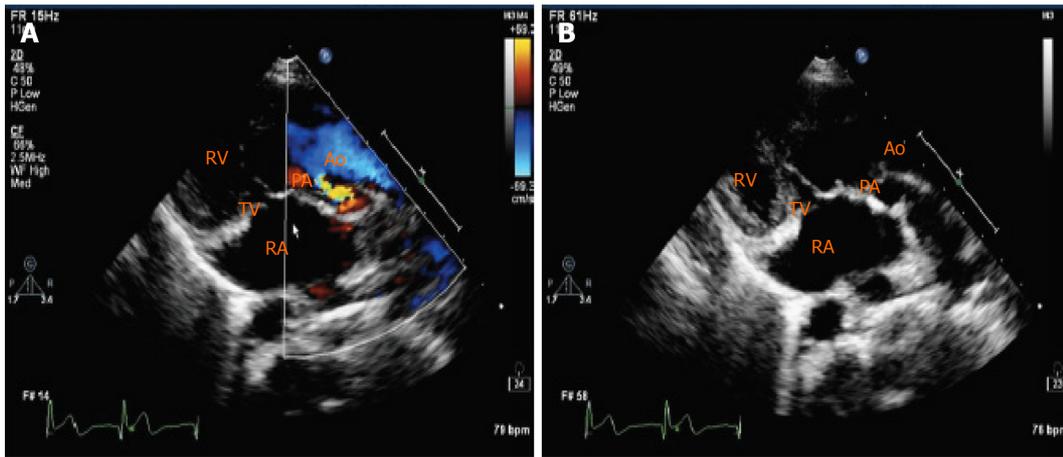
Preoperative transthoracic echocardiography showed a double outlet right ventricle and pulmonary artery stenosis. RA: Right atrium; RV: Right ventricle; TV: Tricuspid valve; Ao: Aorta; PA: Pulmonary artery.
